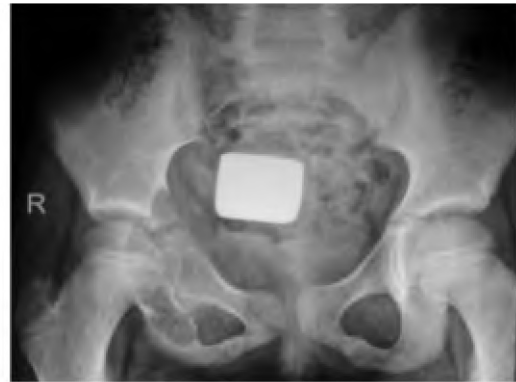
AP radiograph of the pelvis showing ABC involving the roof of the right acetabulum, superior pubic ramus, ischial bone and ramus.
